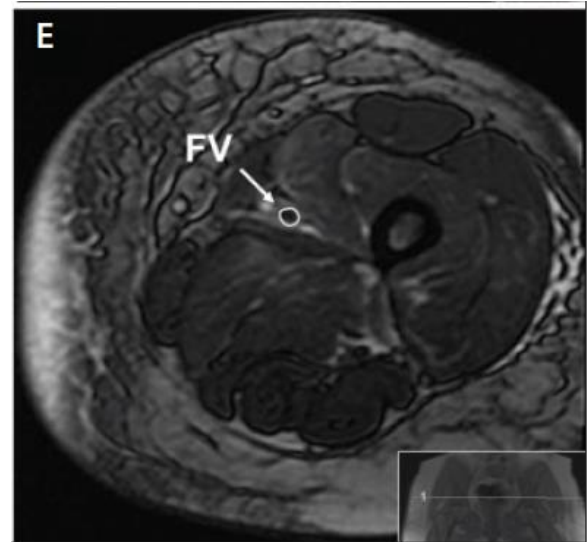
MRI scan with the femoral vein (FV) visible(22)
